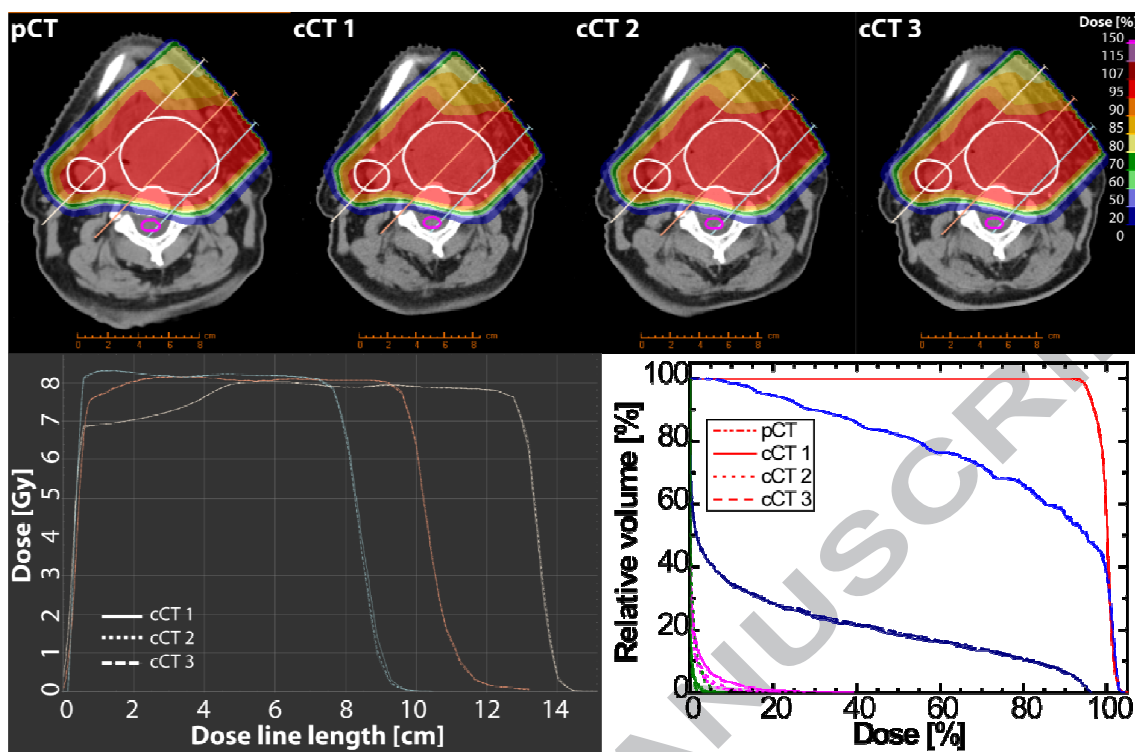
Control CT evaluation. Upper row: Dose distribution of the beam monitored with the slit camera on the planning CT and recalculated on three control CTs. Lower row: Representative line dose profiles (see upper row for location of lines) for the three control CTs. Range variations were below 1.5 mm. DVH for the nominal treatment plan and the three recalculated dose distributions (red: CTV, blue: left parotic gland, dark blue: right parotic gland, purple: spinal cord, green: brain stem). Note, that for cCT3 no DVH for CTV and spinal cord are shown because the CT field of view was too short in caudal direction.
